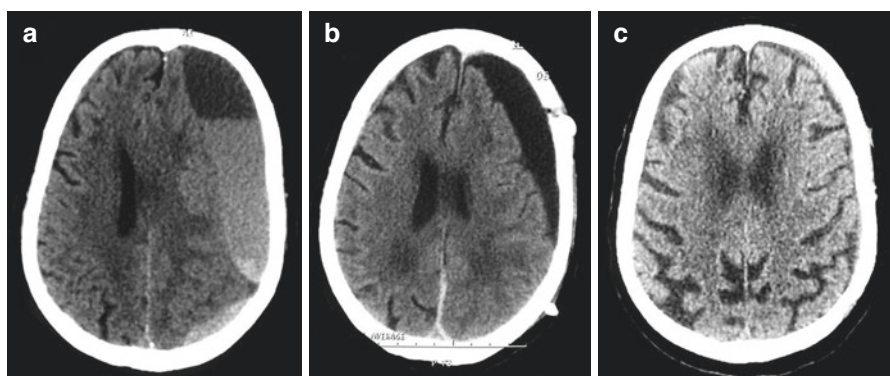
Axial CT scan before (a), at third postoperative day (b), and 3 months after evacuation of a chronic subdural hematoma using two burr holes (c) with a good outcome in an 83-year-old woman
